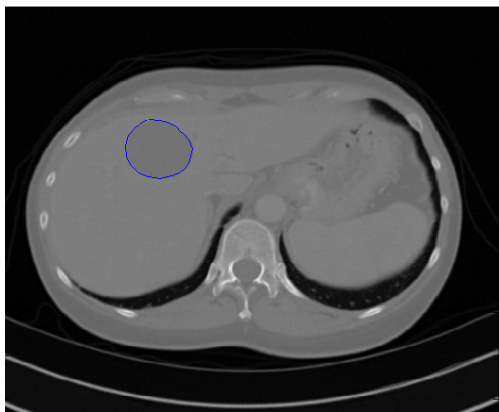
An example of an axial spiral CT slice of the liver with a delineated cystic lesion.
